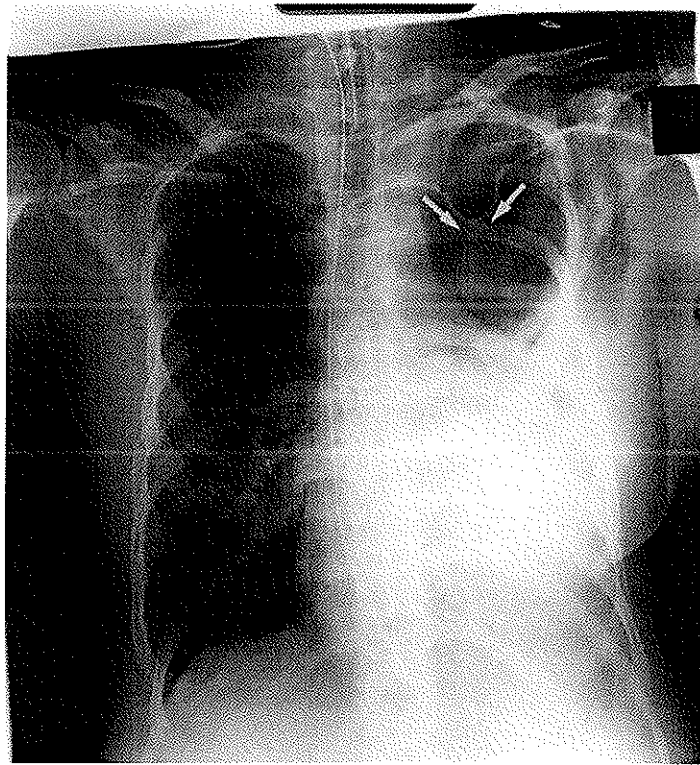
Chest radiograph taken 24 h after the image shown in Fig. 1; the pneumothorax has enlarged, and the lung apex is outlined (arrows). Subcutaneous emphysema and a large pleural effusion are also present. Note the unusual appearance of the central venous catheter.
